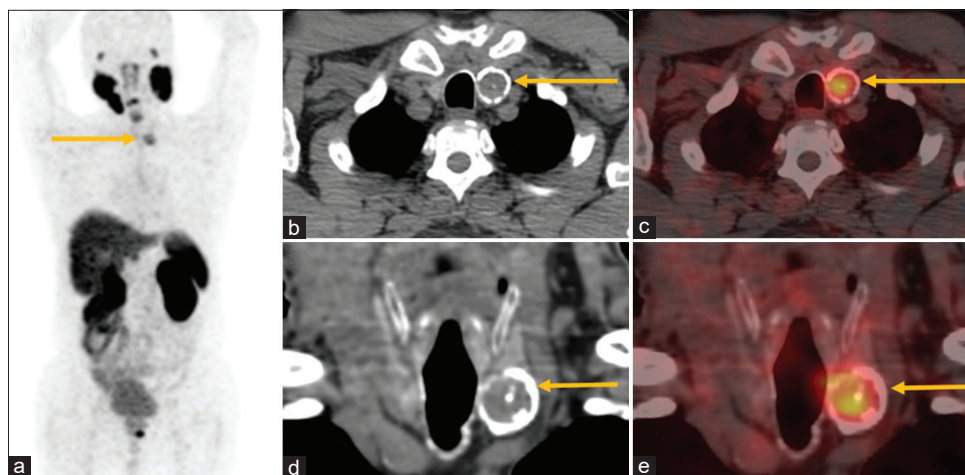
This is a case of a 73-year-old male, adenocarcinoma prostate with a Gleason score of 4+4= 8 and a baseline serum PSA level of 38.95 ng/ml. (a) of 68Ga PSMA PET/CECT scan done for staging shows increased tracer uptake in prostatic lesion (black arrow) and in the neck region (yellow arrow). CT and fused images in axial and coronal planes show increased tracer uptake in the hypodense nodular lesion with peripheral calcification involving left lobe of thyroid (SUVmax 8.17) (b-e; respectively). USG neck reported the lesion as benign and FNAC suggested Bethesda category II (benign).
